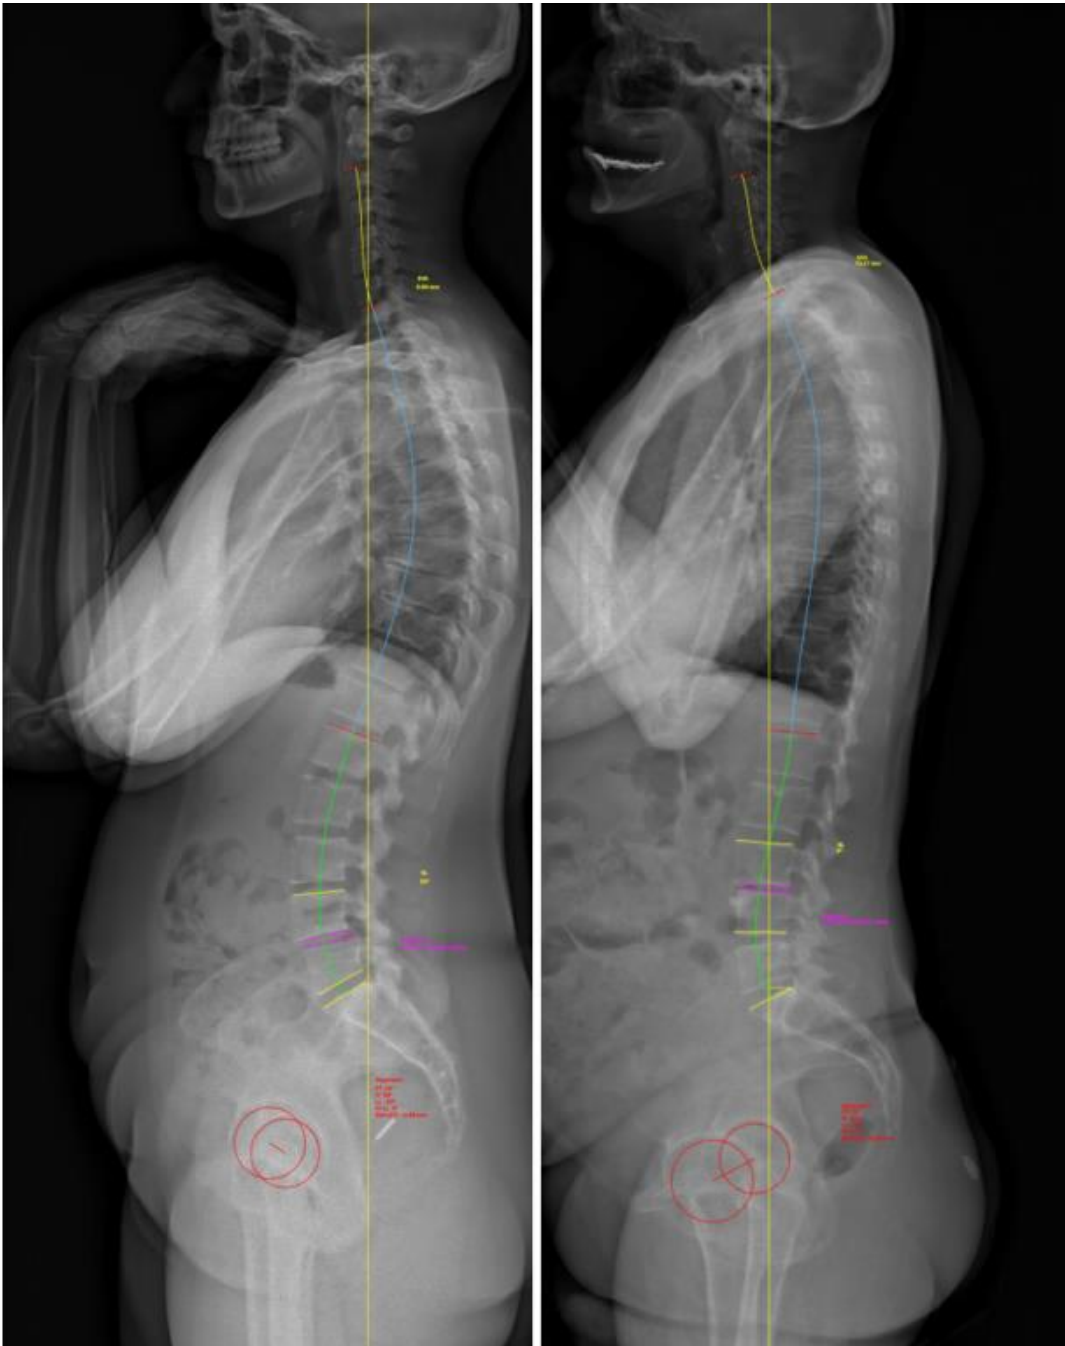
Type 1 on lateral standing low-dose X-ray view. Harmonious and aligned spine
